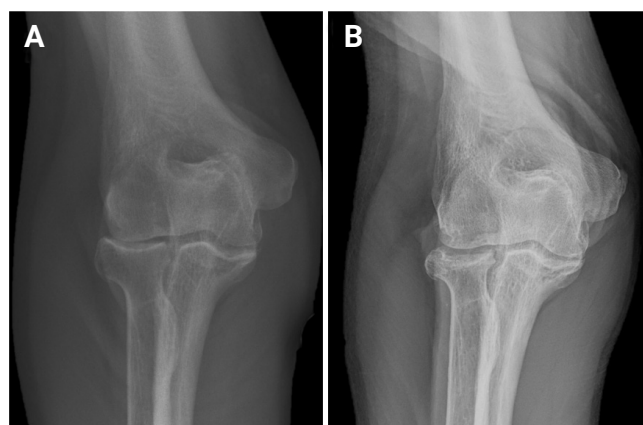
(A) Preoperative and (B) 5.5 years postoperative anteroposterior elbow radiographs of patient no. 8, showing the maintained increased radiocapitellar joint space.
